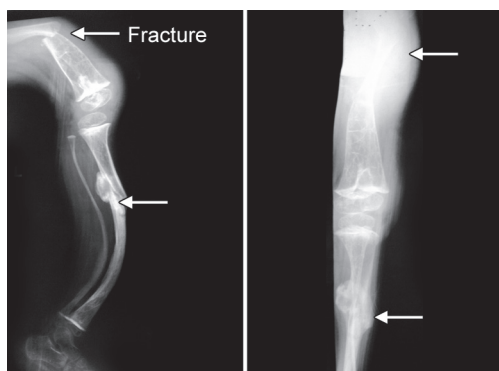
X-ray: Osteogenesis imperfecta (femur and tibia)
